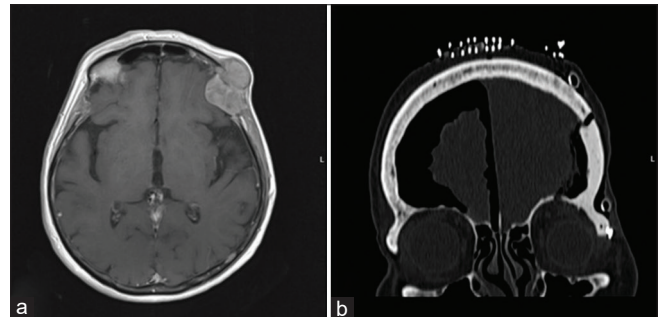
(a) Preoperative contrast-enhanced T1-weighted axial MRI scan revealed an intra- and extracranial metastatic tumor of the left-sided frontal bone, (b) postoperative CT scan revealed the appropriate position of the implant, the left orbit and zygoma were anatomically reshaped.
